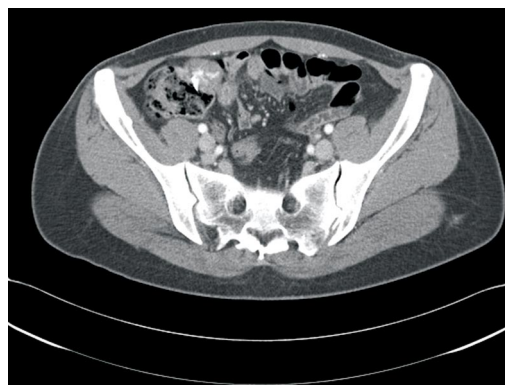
Abdominopelvic computed tomography showing a lesion in the cecum protruding extraluminally with heterogenous enhancement.
